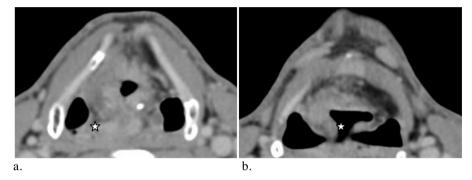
Partial reduction in size of the tumor at contrast-enhanced CT scans at corresponding levels.
